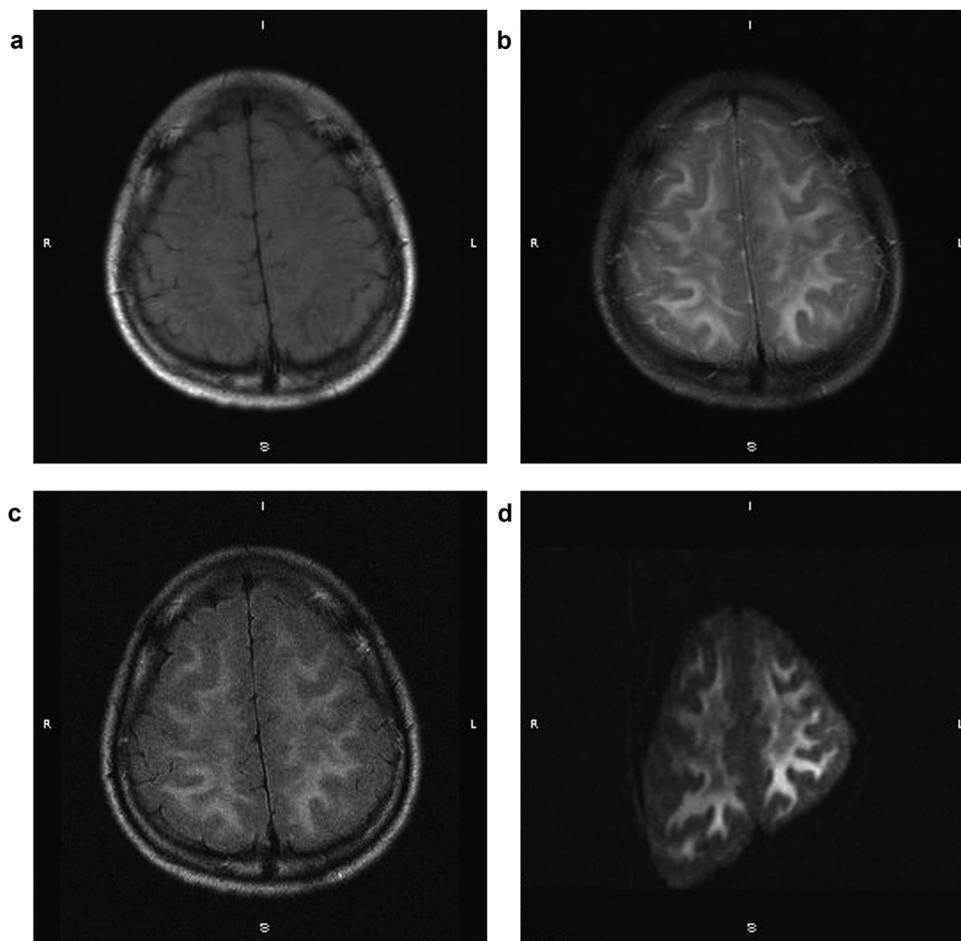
A 42-year-old female worker worked in a poorly ventilated factory for two weeks. Three days later, she was hospitalized for headache, nausea and frequent vomiting. Combined with the investigation of the working environment, the final diagnosis was toxic encephalopathy induced by 1, 2-DCE. T1-weighted images (Fig. 4a) showed low signal intensity lesions with fuzzy boundary involved bilateral subcortical white matters, while on T2-weighted images (Fig. 4b) and Fluid-attenuated inversion recovery (FLAIR) image (Fig. 4c), bilateral symmetrical swelling could be seen in bilateral frontal and parietal cortex, and bilateral symmetrical high signal intensity could also be seen. Despite the distortion of diffusion-weighted images (Fig. 4d) caused by artifacts, bilateral symmetrical hyperintense lesions in the frontal and parietal lobes could be clearly seen. History combined with characteristic imaging findings was helpful for clinical diagnosis.
